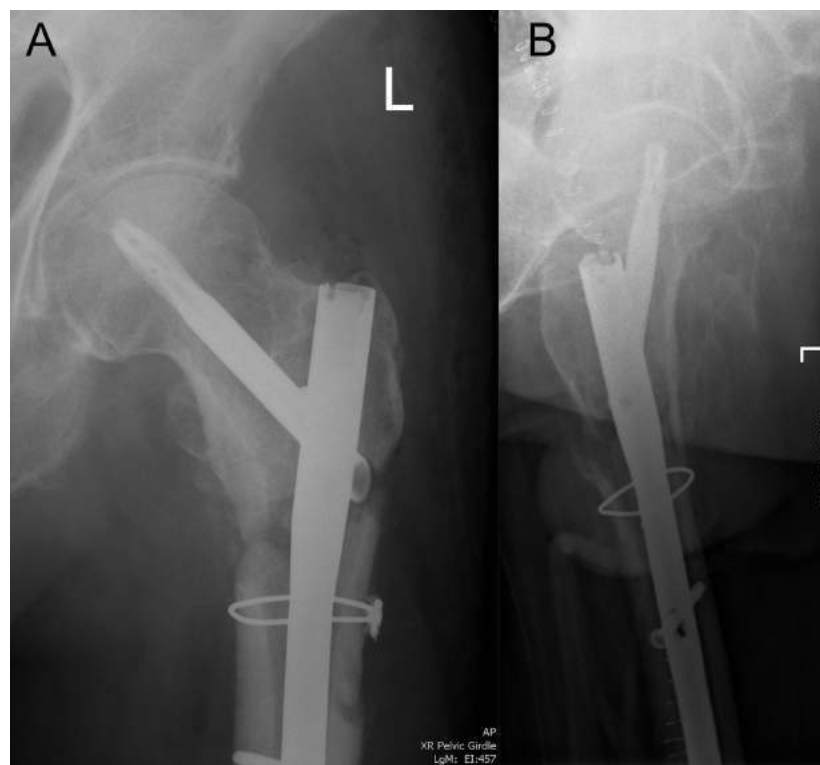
X-Rays Post Revision for Case 3
